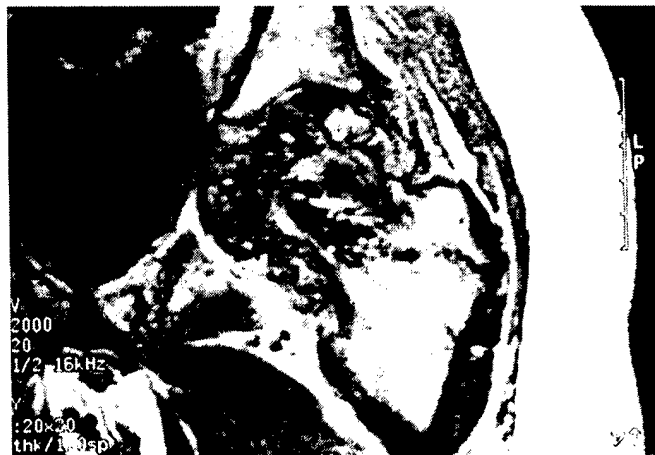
MRI at 1 year demonstrating significant changes within the femoral head, but no significant collapse.
